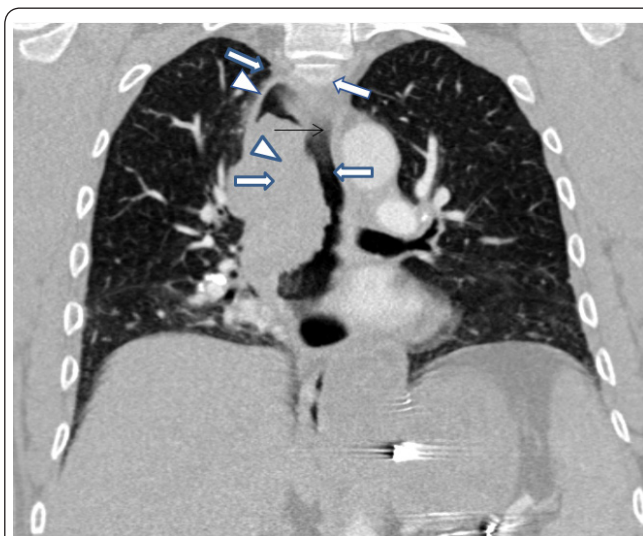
Coronal reformatted image from contrast enhanced chest CT. Esophageal mass is demonstrated with superior and inferior extent indicated by white arrowheads. Dilated esophageal lumen is shown both proximal and distal to the mass (white arrows). Lumen remains patent at the level of the mass (thin black arrow), despite the large size of the mass.
